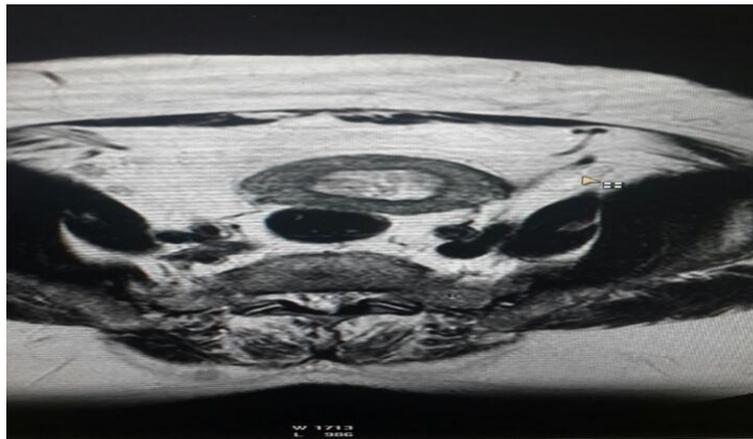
Axial view T2 MRI image show endometrial mass.
